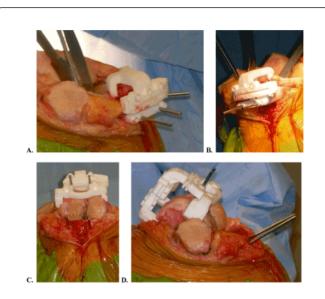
Intra-operative photographs of tibial (A, lateral-sided view; B, medial-sided view) and femoral (C, end-on view; D, lateral-sided view) CT-based, mechanical axis-aligned customised cutting jigs pinned in place. Intimate contact and a perfect fit with the patient's bone are sine qua non for accurate bone resections.
